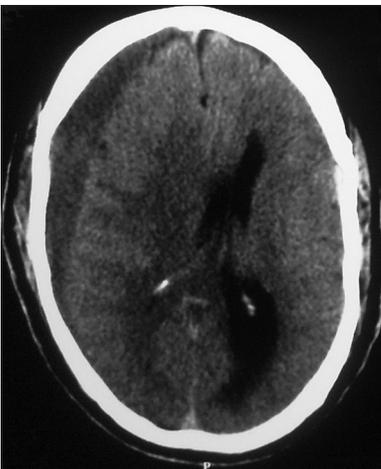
CT Brain showing subdural hematoma
